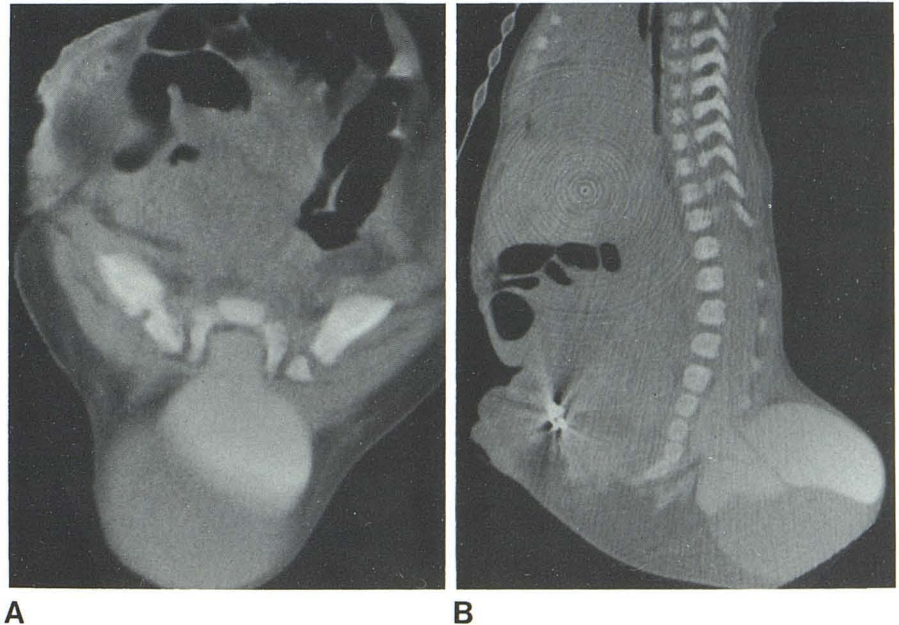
Case 3. Lipoma with dysraphism. A, Direct midline sagittal CT scan with metrizamide. Low cord merging with large, subcutaneous lipoma that blends through dura. B, Off-midline sagittal CT image. Density within lipoma consisting of aberrant cartilage and bone. C, Postmetrizamide axial images.
